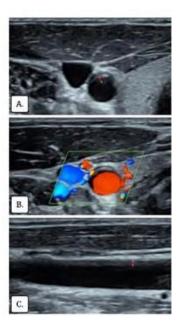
Doppler ultrasound showing dissection of right the common carotid artery. A. On transverse view (*arrow*). B. Color doppler flow image with careful adjustment of colour gain detected the intimal flap. C. On longitudinal view (*arrow*).
